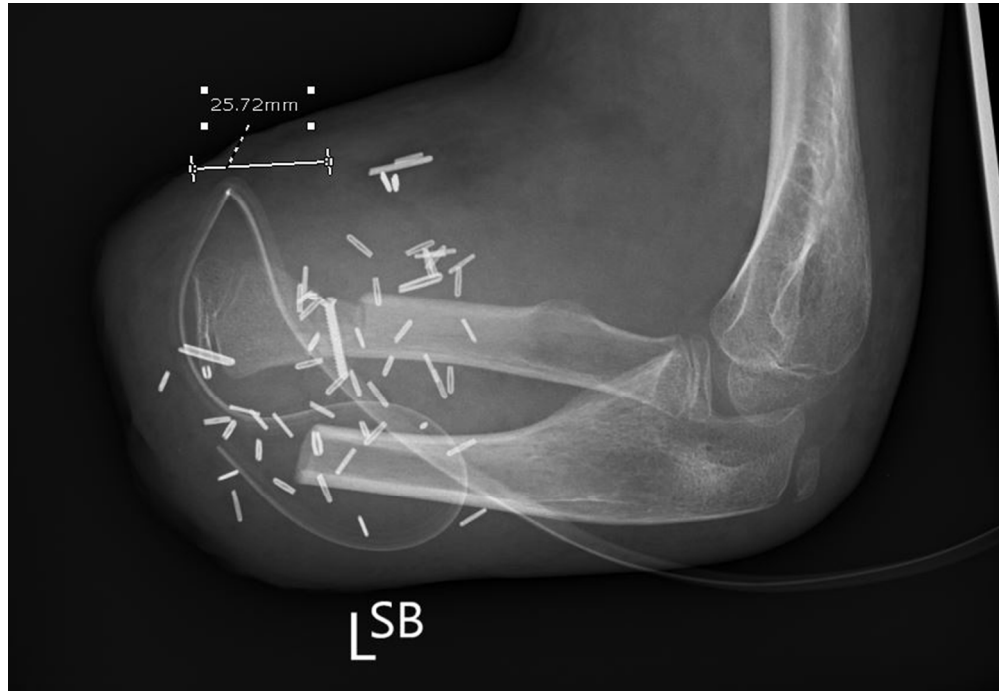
2b & 2c. (a) Lympho-venous malformation of the hand prior to amputation. (b) Immediate post-operative x-ray of the distal radius used to cap the amputation stump. (c) X-ray 1 year post-operatively showed 6mm growth of the radius from the distal epiphysis with no signs of bony overgrowth.
